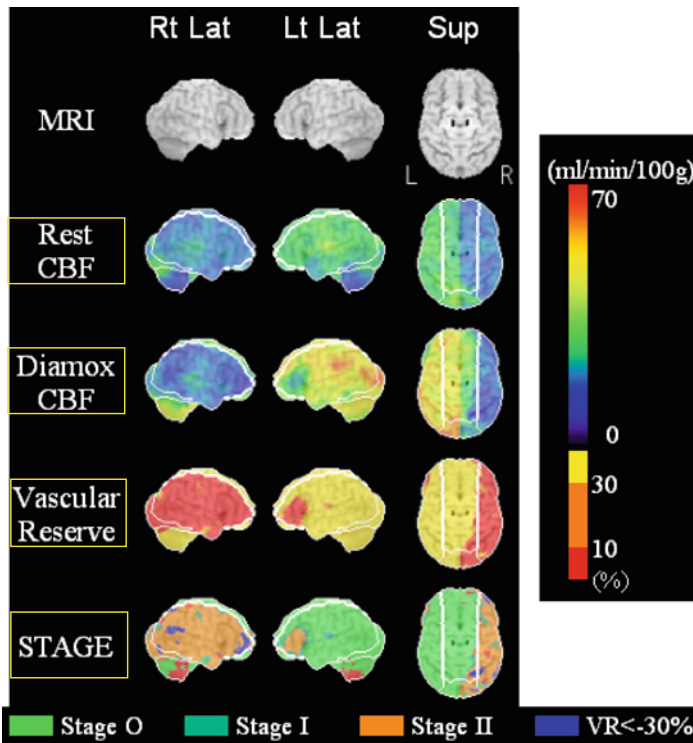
Stereotactic extraction estimation (SEE) JET analysis and stratification of hemodynamic cerebral ischemia using quantified CBF-SPECT: SEE-JET analysis using standardized brain surface template and DTARG for patient in Fig. 4 showed a moderate decrease of resting CBF, no increase of DIAMOX-activated CBF, loss of vascular reserve, and Stage II ischemia in the right whole MCA territory. Stratification of hemodynamic cerebral ischemia using quantified CBF-SPECT was
